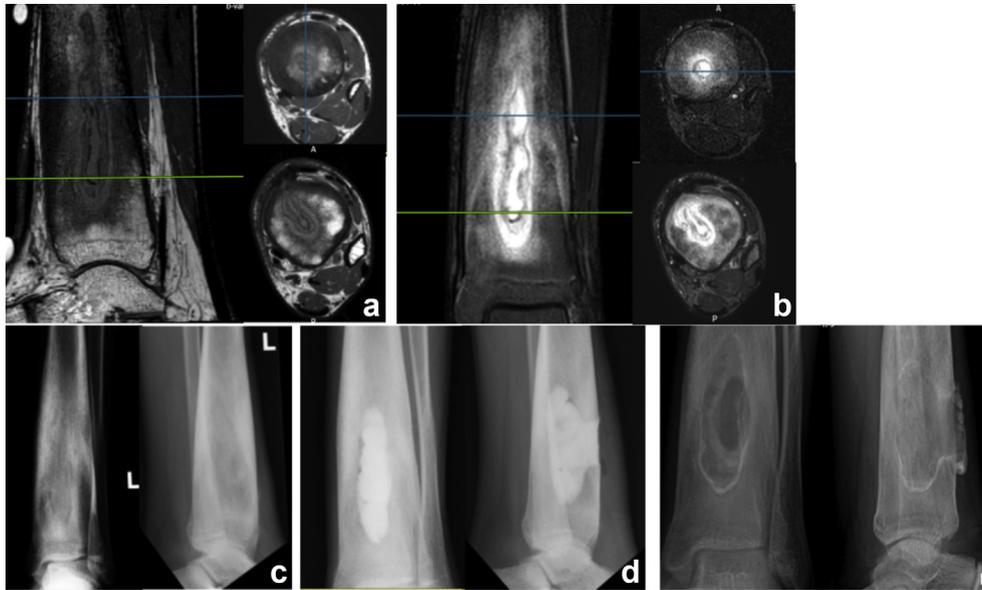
Preoperative T1 (a) and STIR (b) MRI images and plain radiograph (c) of patient with Brodie's abscess distal tibial (Cierny–Mader Type 1). Radiographs of immediate postoperative period showing anterior cortical window used to access abscess and the use of bioceramic to fill void (d). Radiographs at 6 months postoperative (e) showing complete resorption of bioceramic, good void filling of bone, and early cortication of the anterior window.
